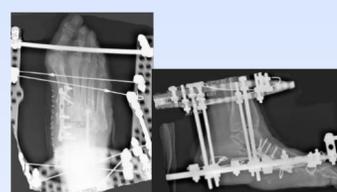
Postoperative radiographs of the patient in Figure 4, showing excellent realignment of the medial longitudinal arch with the plantar plate. Also note the lateral column beaming.
